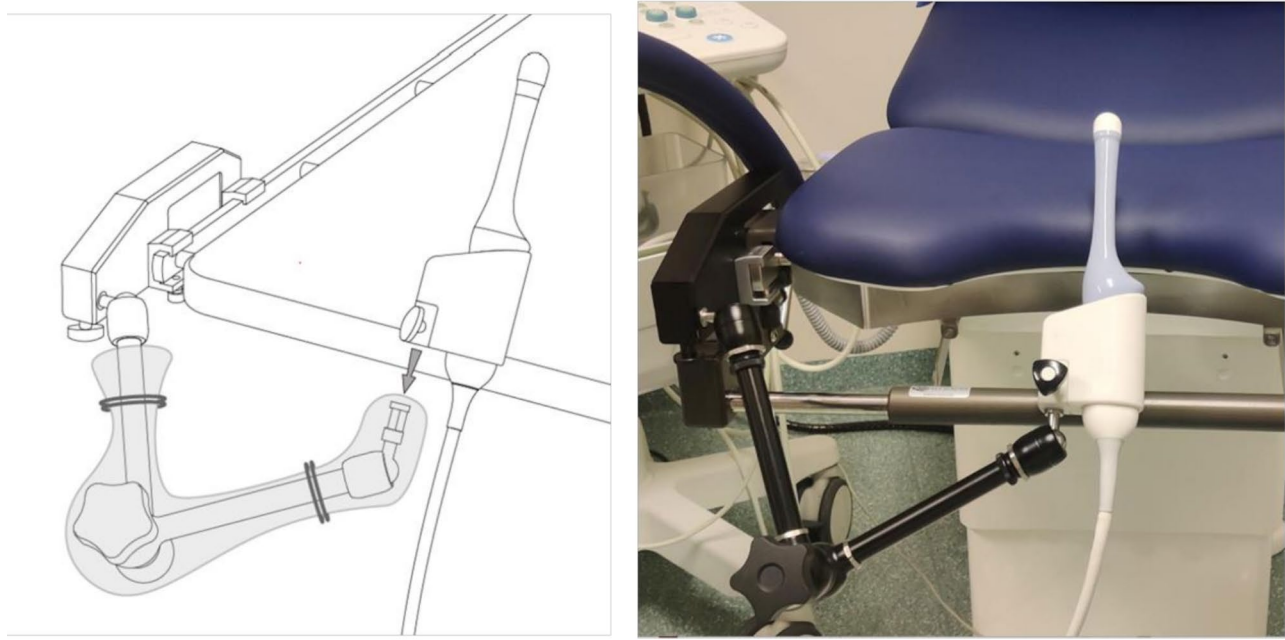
probe fixture. The probe fixture is attached to the DIN-rail and is used to fix the ultrasound probe in a position to ensure optimal and stable image acquisition
